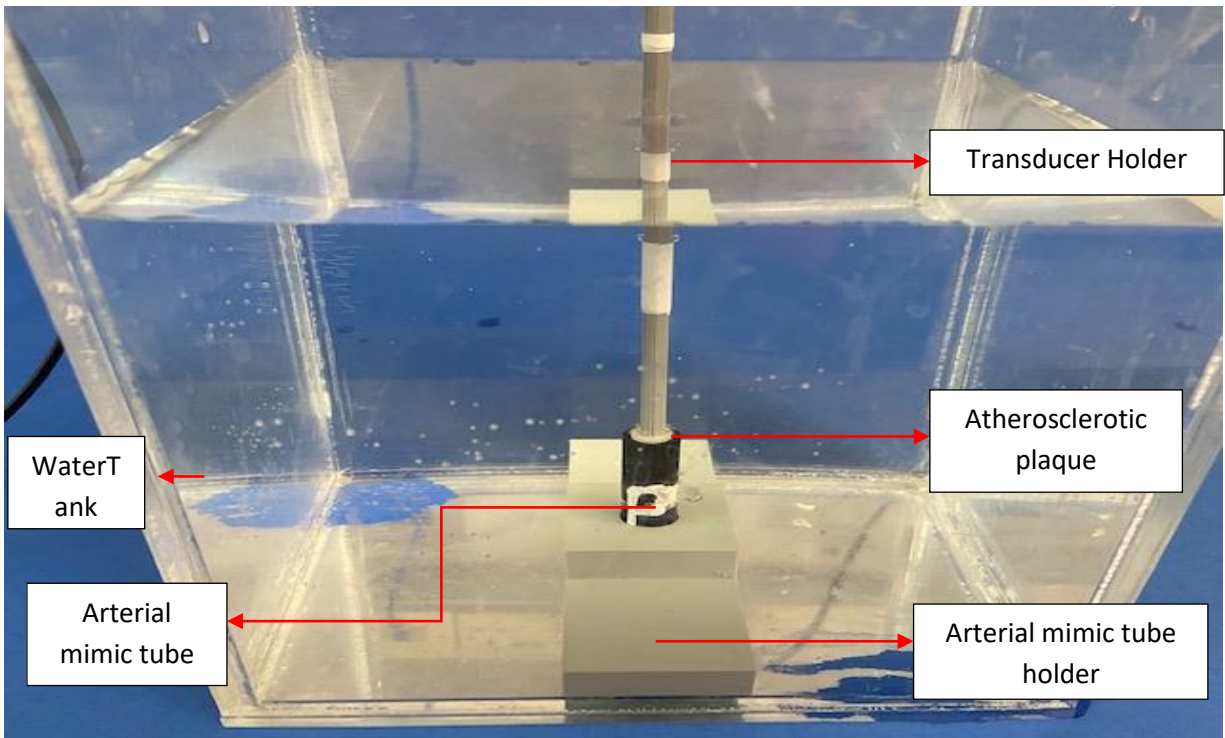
Experimental setup for investigating the ability of therapeutic ultrasound to ablate atherosclerotic plaque using a new arterial mimic tube holder.
